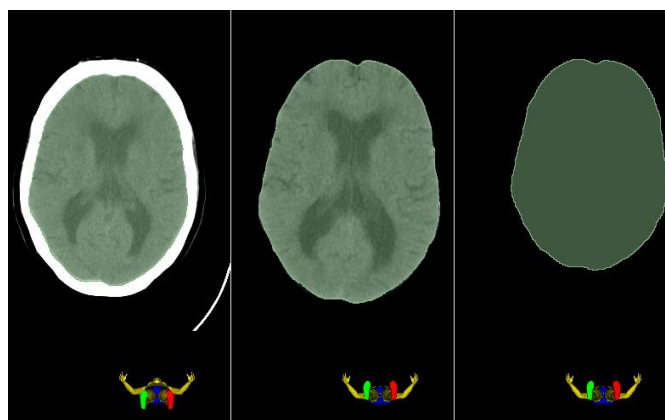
Axial sections of CT images, extracted brain tissue and corresponding segment
